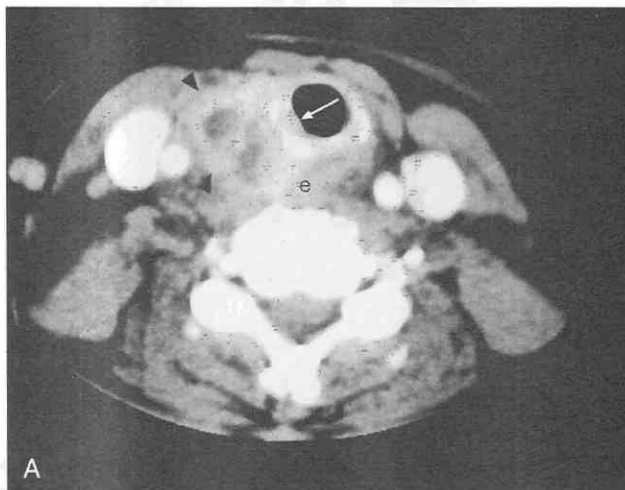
A, Axial postcontrast CT shows a heterogeneously enhancing mass (arrowheads) within the right thyroid lobe, with invasion of the cricoid ring and submucosal extension of tumor (arrow). e, esophagus. B, CT image in the same patient at a lower level shows the mass invading the trachea and esophagus (e). Papillary carcinoma was found at surgery.
